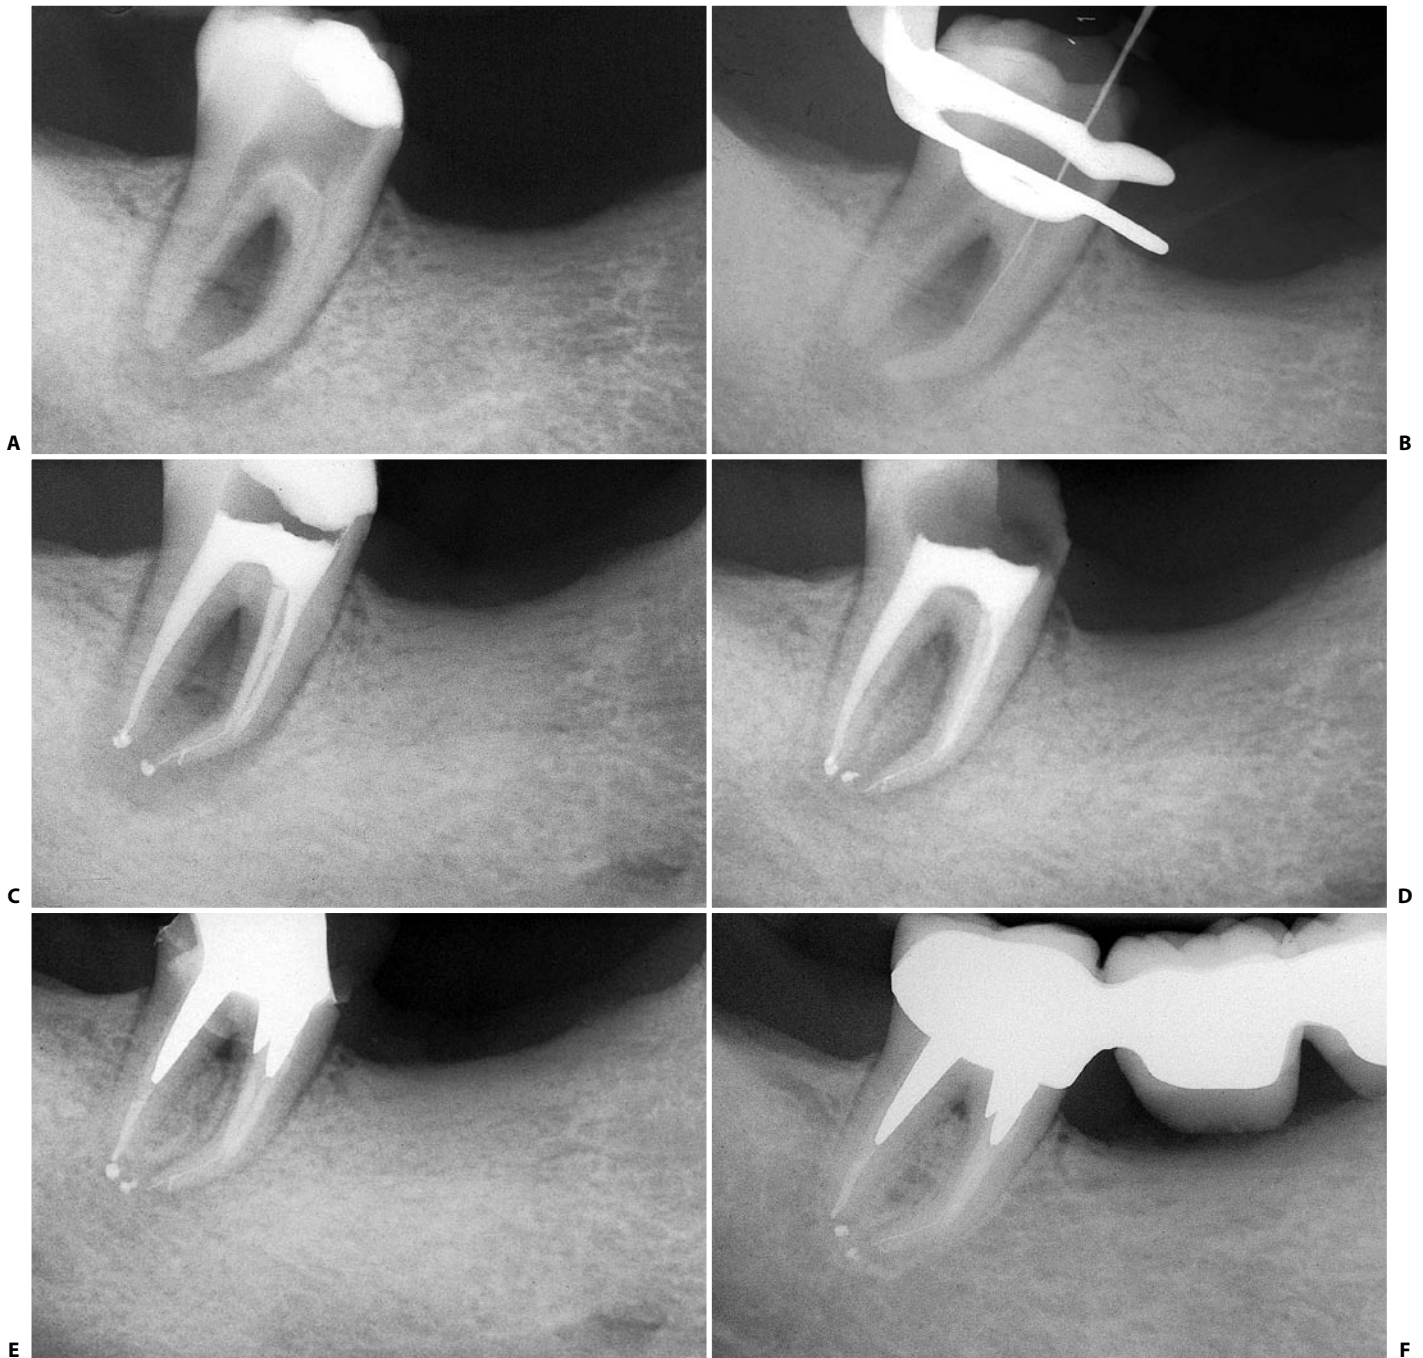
A. Preoperative radiograph of a lower right second molar. The patient was referred after the distal canal had been prepared and the mesial canals were found to be partially negotiable. B. The mesial canals are blocked by a ledge at the beginning of the curve of the root. C. Postoperative radiograph. The distal canal has been obturated with warm gutta-percha, and the mesial canals with thermoplastic gutta-percha. Note the filling of the non-instrumented portion of the mesial canals. D. Radiograph five months later. E. Eleven months later. F. Three year recall.
